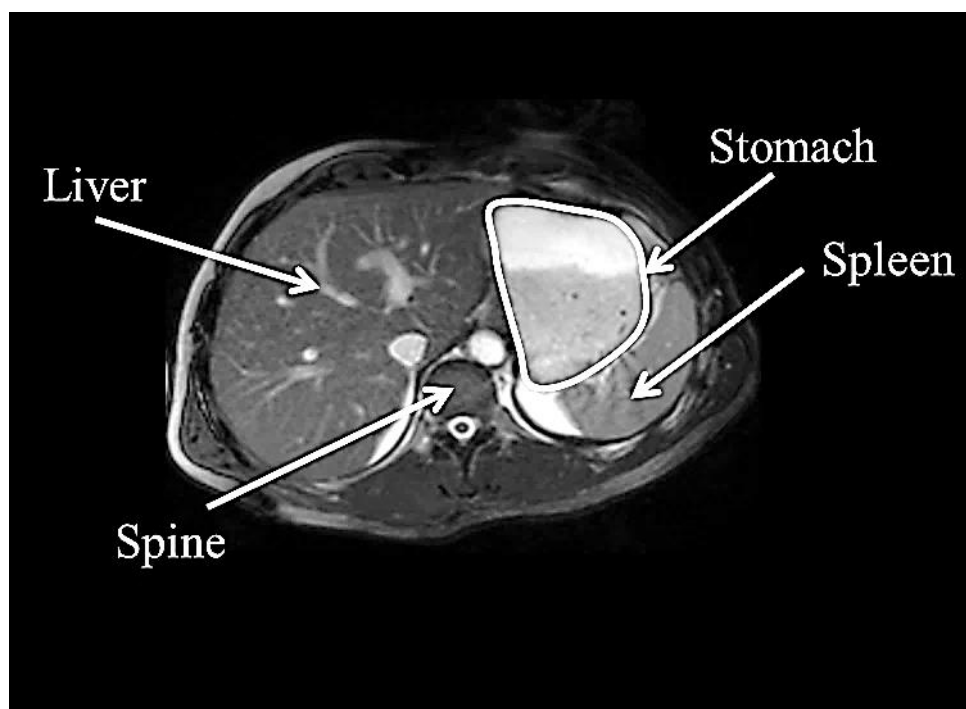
Representative example of axial MRI images of the abdomen of a healthy volunteer fed with pearl millet porridge (PMP).
